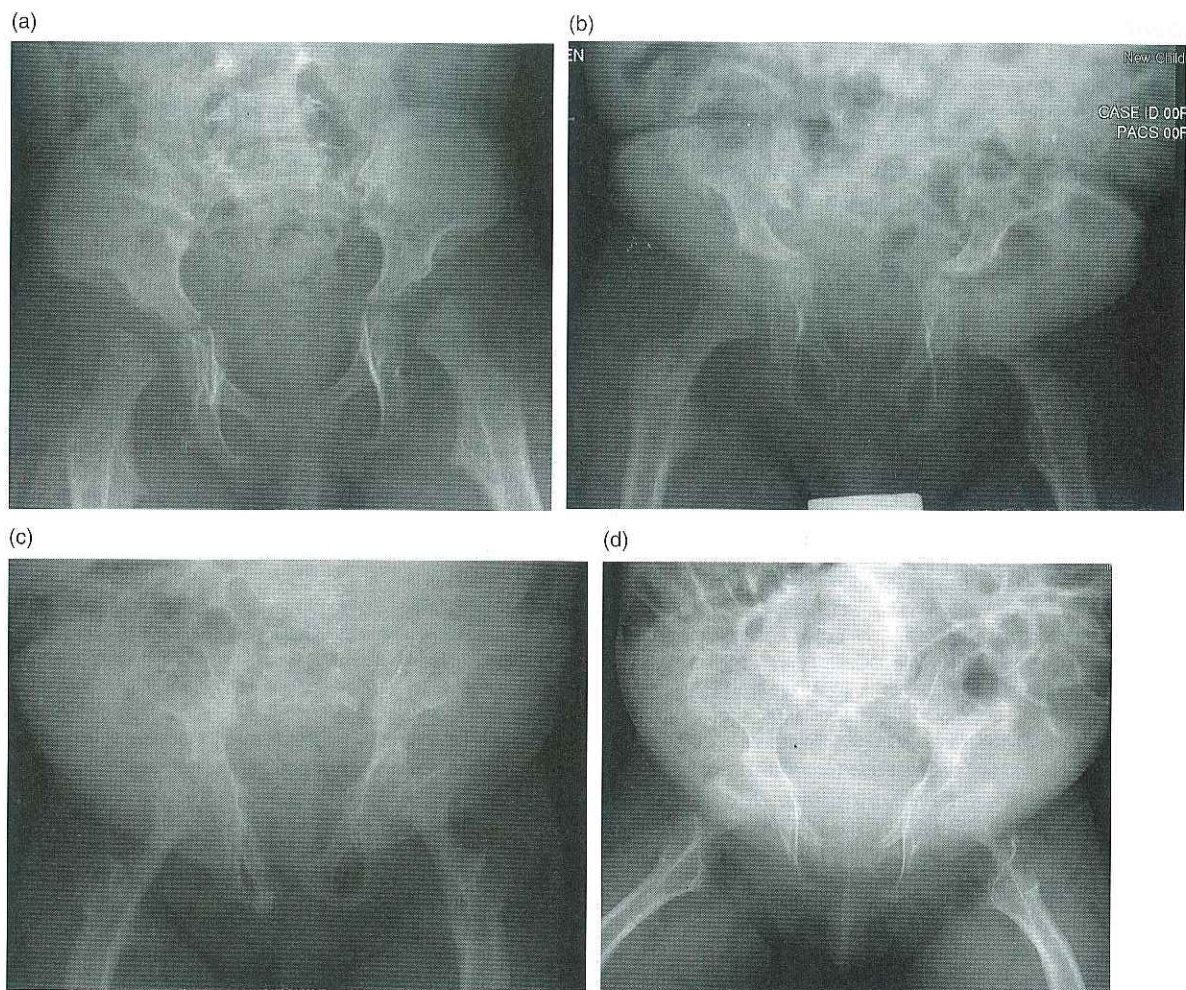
Radiograph of pelvis and proximal femurs in four affected with intermediate aged (a) 4 years, (b) 16 years, (c) 18 years and (d) 19 years. showing progressive dysplasia/resorption of the low third of the ilia femoral heads and femoral necks.
